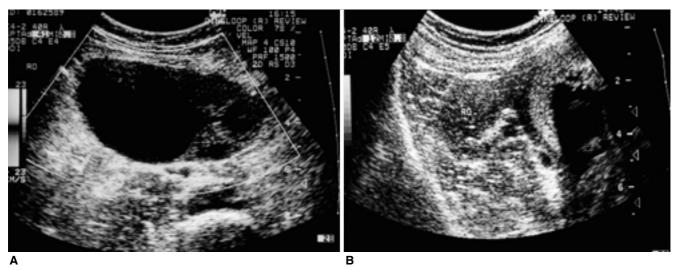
Thirty-one year old patient with 720 degree torsion of the right ovary at 6weeks of twin gestation. A. Transabdominal CDS shows no blood flow of the ovary and cystic mass. B. Subsequent follow-up sonography after detorsion with cystectomy shows a normal ovary(RO) with presence of flow(not shown).
